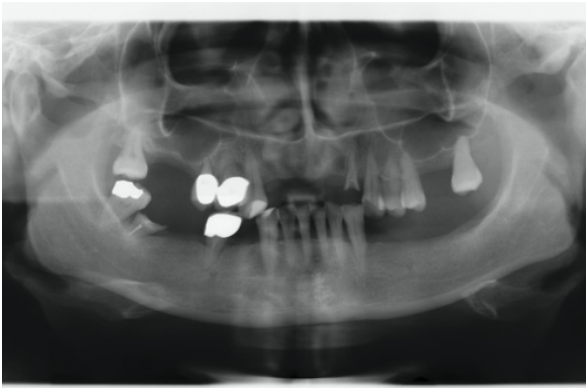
Initial OPG radiograph.
